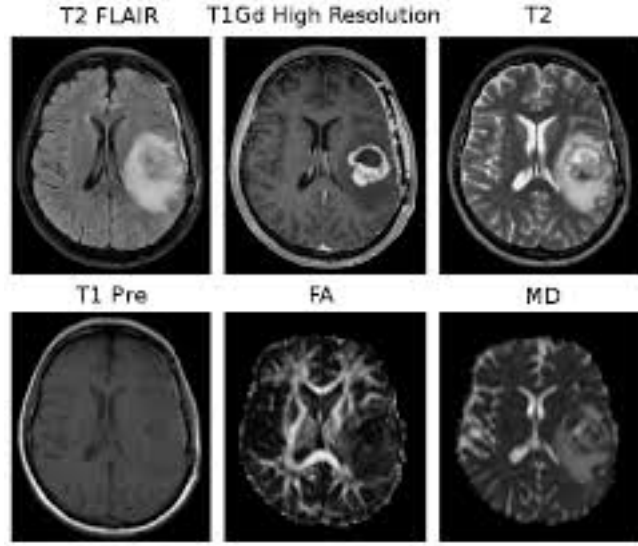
Various MRI modalities used in diagnosis of glioblastoma [15].
